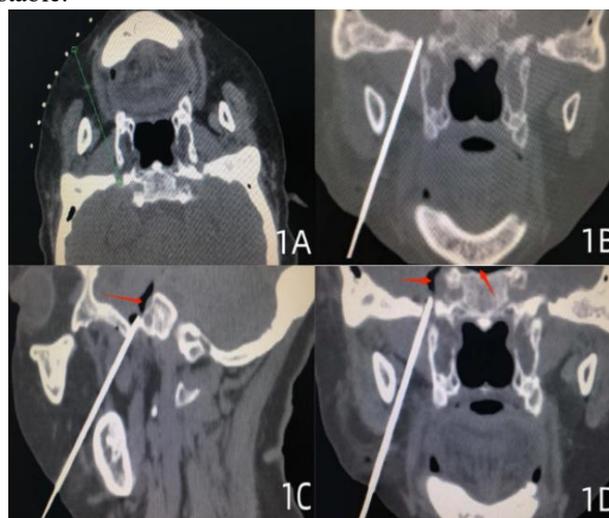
CT-guided ozone neurolysis of the Gasserian Ganglion.
